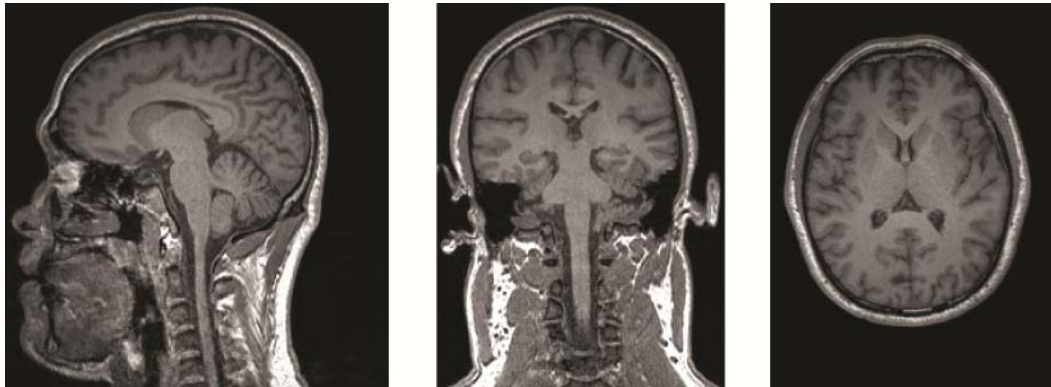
Representative sagittal, coronal, and axial MR images of the head (1 mm resolution).
